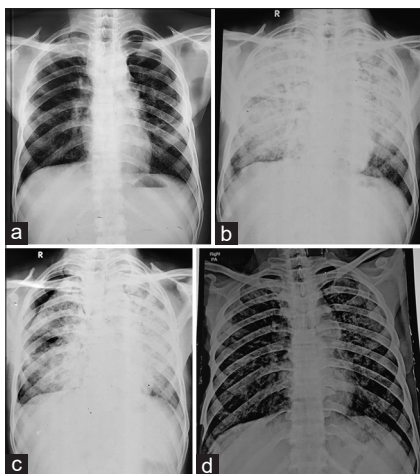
X-ray of the chest showing bilateral diffuse fine nodular shadows (a); bilateral consolidation (b); right-sided pneumothorax (c); and patchy fibrotic lesions (d)
